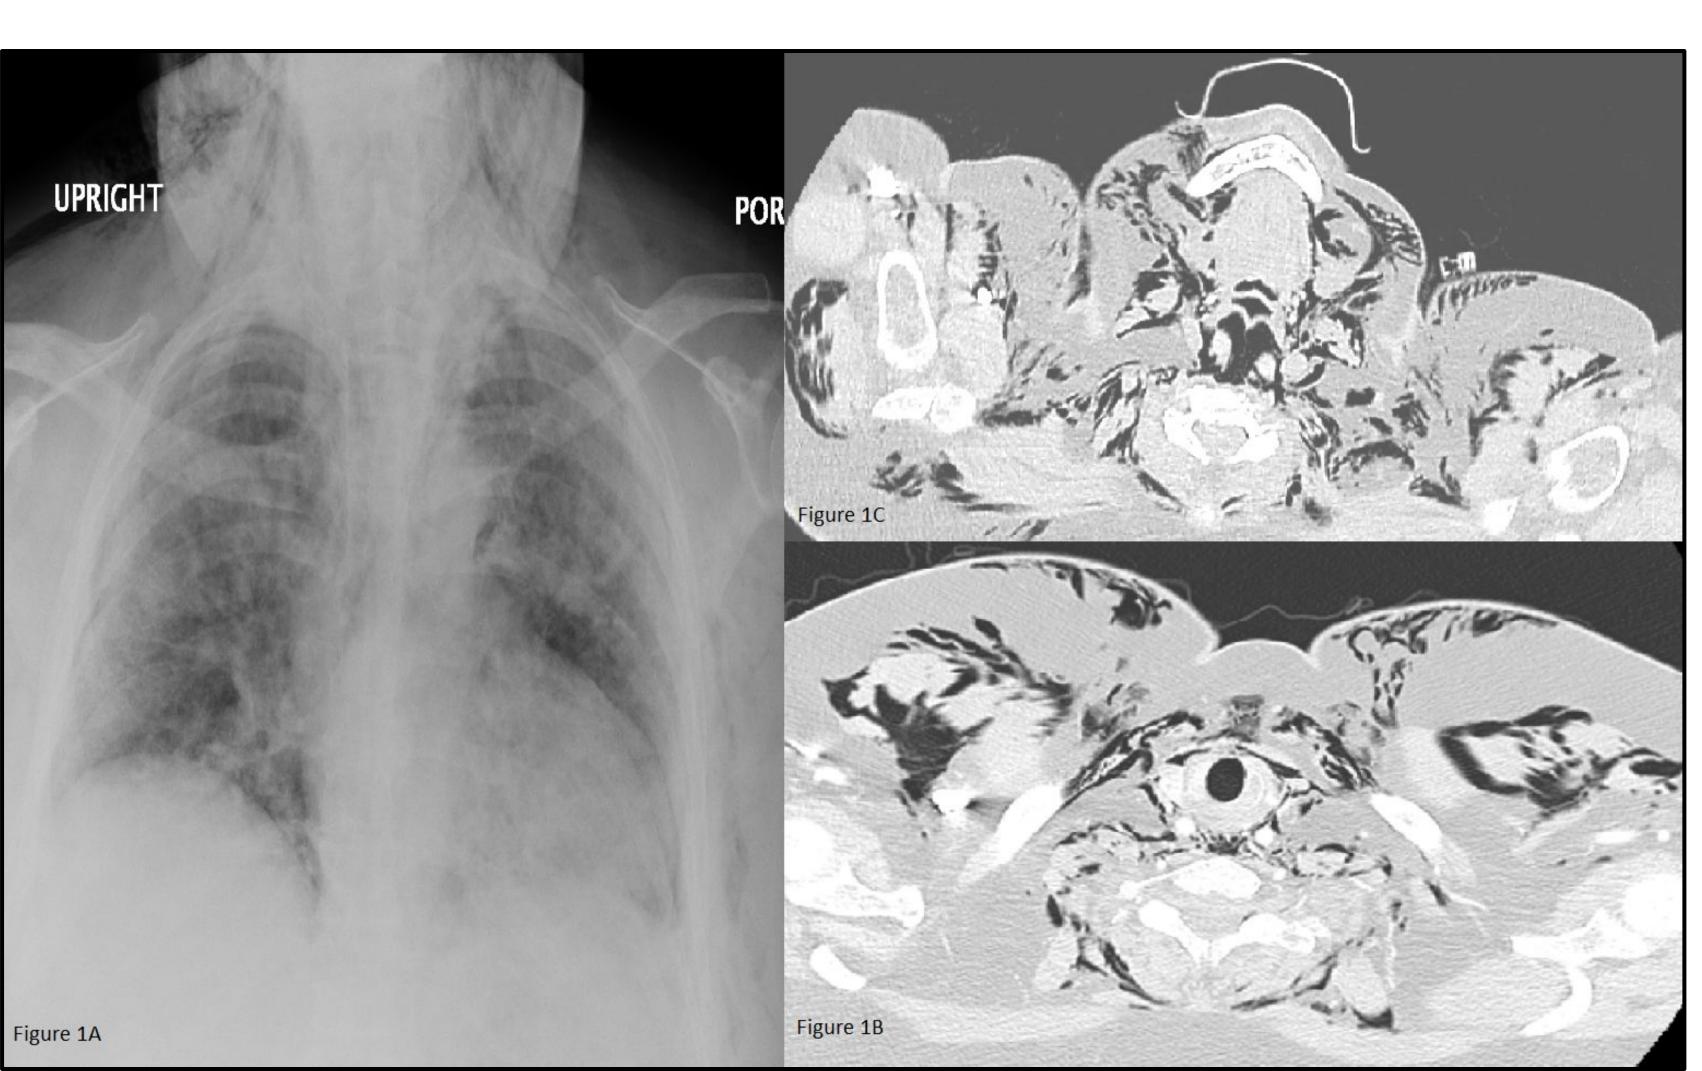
Chest x-ray showing subcutaneous emphysema (SSE). Figure 1B: Chest computer tomography (CT) scan showing extend of SSE. Figure 1C: Worsening of chest CT scan showing extend of SSE.
